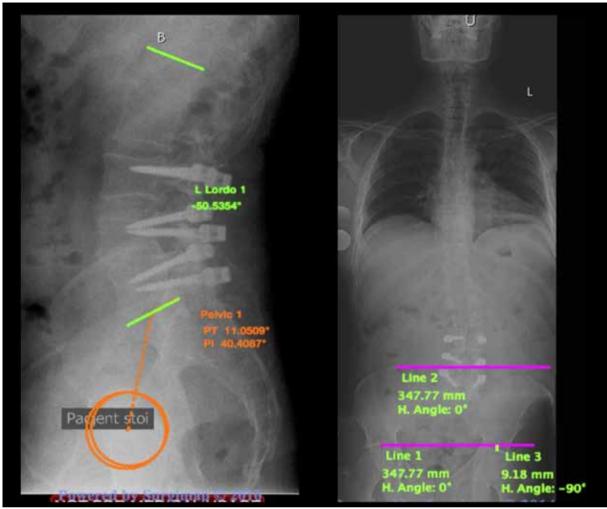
Lumbar spine – lateral and whole spine AP radiographs after the first surgery, before revision.
